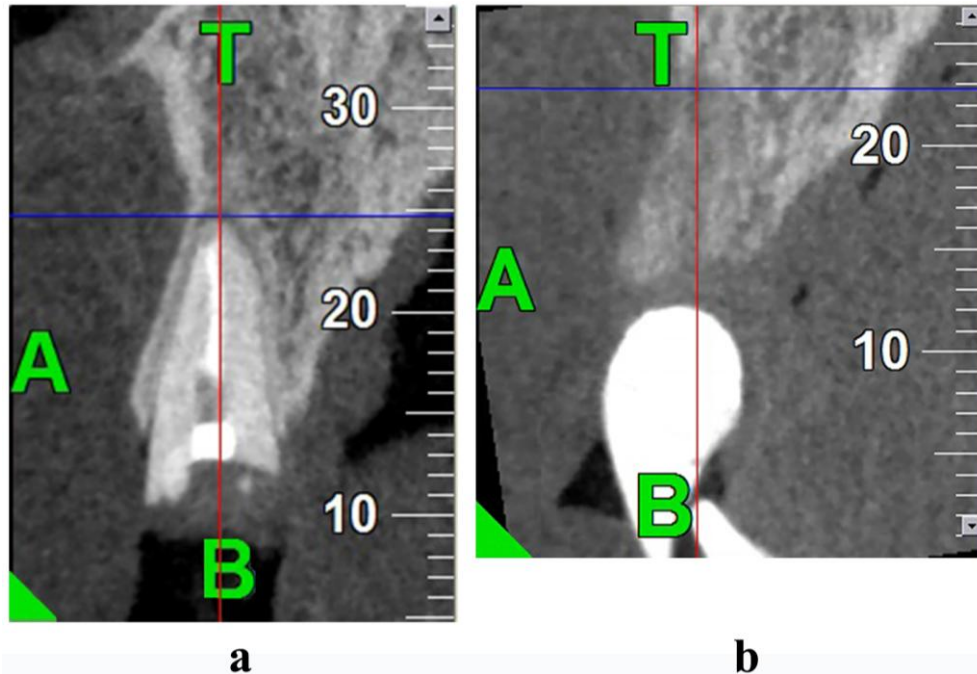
(a) CBCT scans before tooth extraction and (b) after 6 months with provisional restoration.
